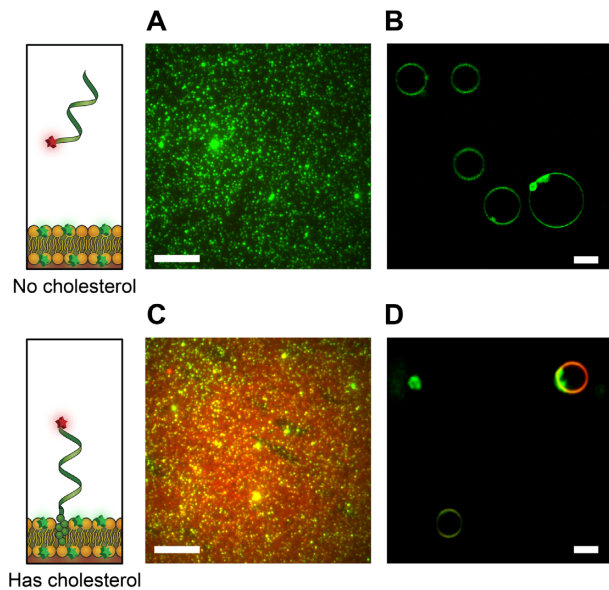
Binding of cholesterolated DNA to liposomes. (A) Merged two-colour TIRF images of ssDNA Alexa647–DNA oligomer (red) at 100 nM concentration and PE-rhodamine-labelled DOPE/DOPC SUVs (green). C_R for image in (A) is 1.0332. (B) Confocal image of ssDNA Alexa647–DNA oligomer (red) at 5 nM and rhodamine-labelled DOPE/DOPC GUVs (green). (C) Merged two-colour TIRF images of ssDNA Alexa647–DNA–cholesterol oligomer (red) at 100 nM concentration and PE-rhodamine-labelled DOPE/DOPC SUVs (green). C_R for image in (C) is 1.9436. (D) Confocal image of ssDNA Alexa647–DNA–cholesterol oligomer (red) at 5 nM and rhodamine-labelled DOPE/DOPC GUVs (green). For TIRF images (A, C, 16 bit), brightness is scaled with min = 1500 au and max = 7000 au. For GUVs, image scaled (B, D, 8 bit) with min = 30 and max = 255. For all images, buffer conditions are 210 mM sorbitol and 5 mM Tris–HCl, pH 7.5; for (A, C), NaCl 25 mM; for (B, D), NaCl 50 mM. All scale bars: 10 μ m.
